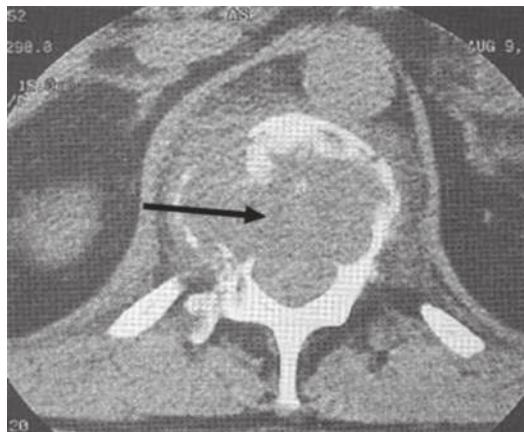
The CT scan image of a person showing metastatic destruction of the vertebral body (black arrow).
